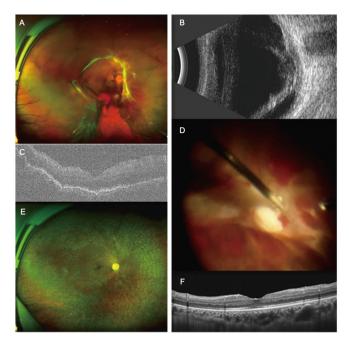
A patient with proliferative diabetic retinopathy in the right eye underwent 27-G vitrectomy. (A) Preoperative SLO showing VH with severe fibrovascular membranes and TRD at the posterior pole. (B) Preoperative B-ultrasound scan showing vitreous turbidity, fibrovascular membranes and TRD. (C) Preoperative OCT was not definitive concerning the presence of VH. (D) Intraoperative image obtained during 27-G microincision vitrectomy surgery. The fibrotic membrane could be segmented and dissected using 27-G vitrectomy with only slight intraoperative bleeding. (E) SLO and (F) OCT obtained 3 months after surgery showing that the retina had reattached successfully. 27-G, 27-gauge; VH, vitreous haemorrhage; TRD, tractional retinal detachment; OCT, optical coherence tomography; SLO, scanning laser ophthalmoscopy.
